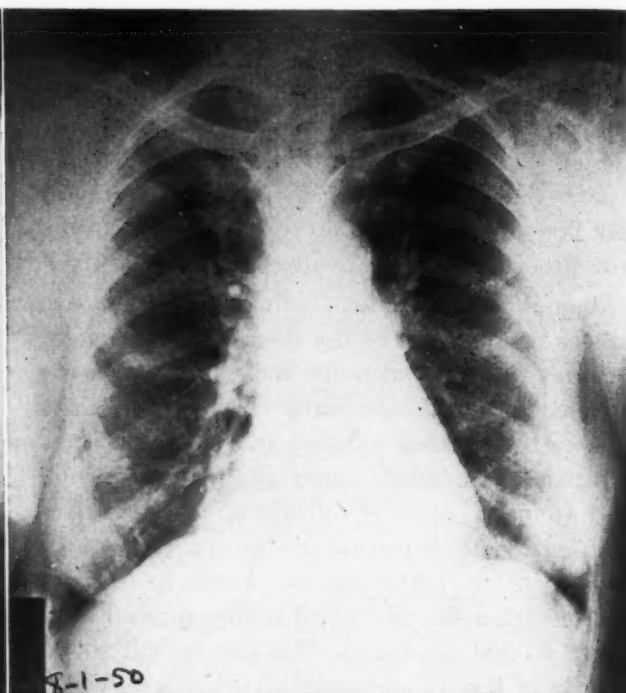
X-ray of patient four and one-half months later, after treatment with Magnesium Tracinate, showing no metastases.
